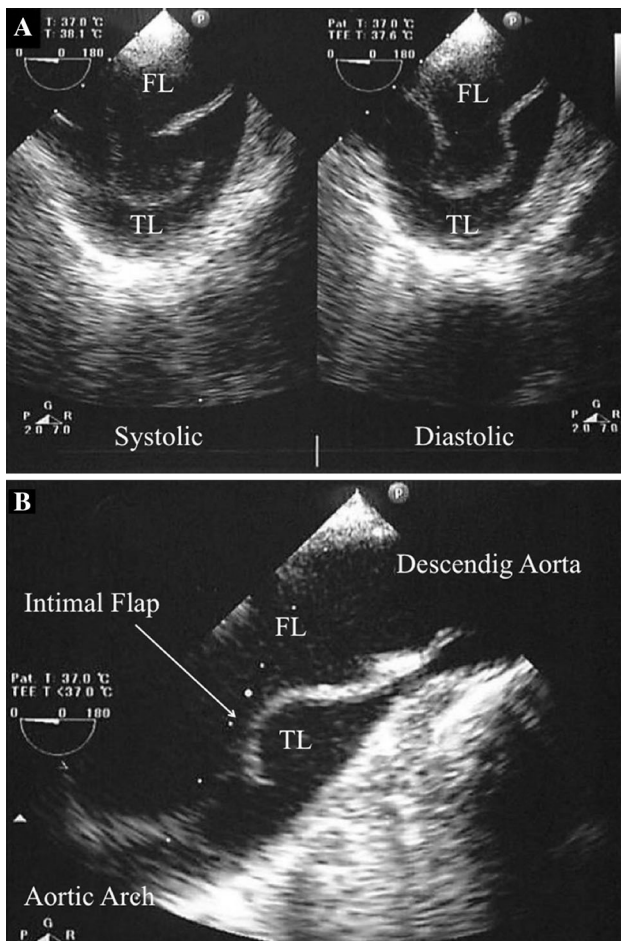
Intraoperative transesophageal echocardiographic evaluation of aortic dissection. a Transesophageal echocardiography findings before cardiopulmonary bypass showed the entry of the aortic dissection on the lesser curvature of the distal aortic arch. The to and fro movement of the intimal flap was synchronized with the cardiac cycle. We could distinguish the true lumen from the false lumen because the lumen indicated TL in the figure lead to the left ventricle. b The intimal flap started fluttering after right axillary arterial perfusion, suggesting a relationship between the intimal flap's movements and the blood flow of the cardiopulmonary bypass via the innominate artery. Further, the entry of the aortic dissection remained open due to a deformed intimal flap, and the enlarged false lumen compressed the true lumen. *TL* true lumen, *FL* false lumen
